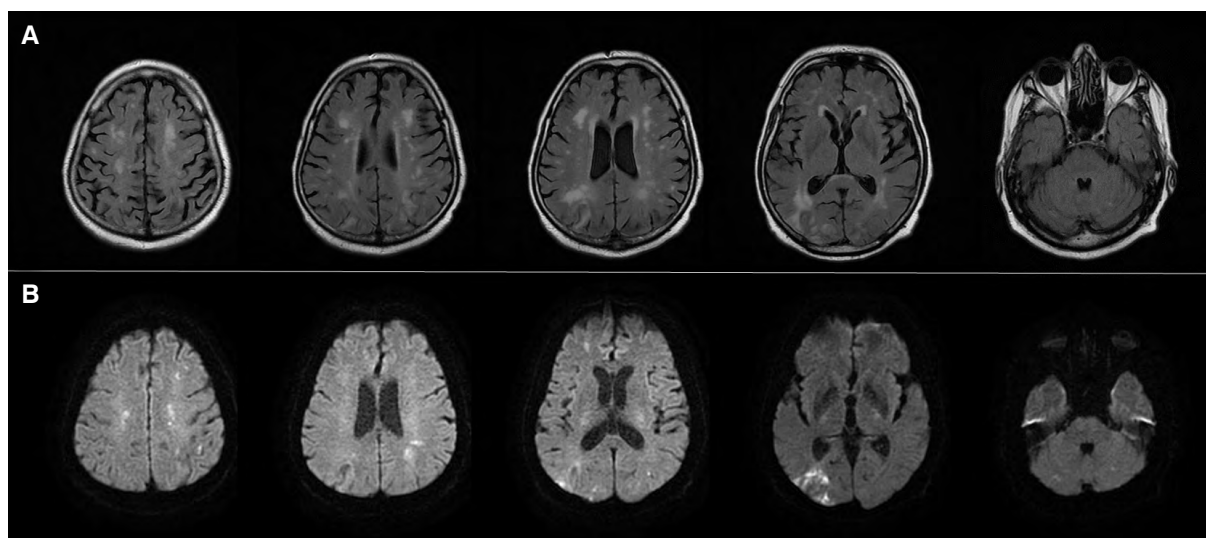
(A — FLAIR; B — DWI). Numerous diffuse hyperintense lesions and striae, some with restricted diffusion (recent ischaemia). The largest area of restriction is clearly visible in the right occipital area. Many lesions and bands of enhancement are visible along cortical gyri; several similar enhancement bands are visible in both hemispheres of the cerebellum
